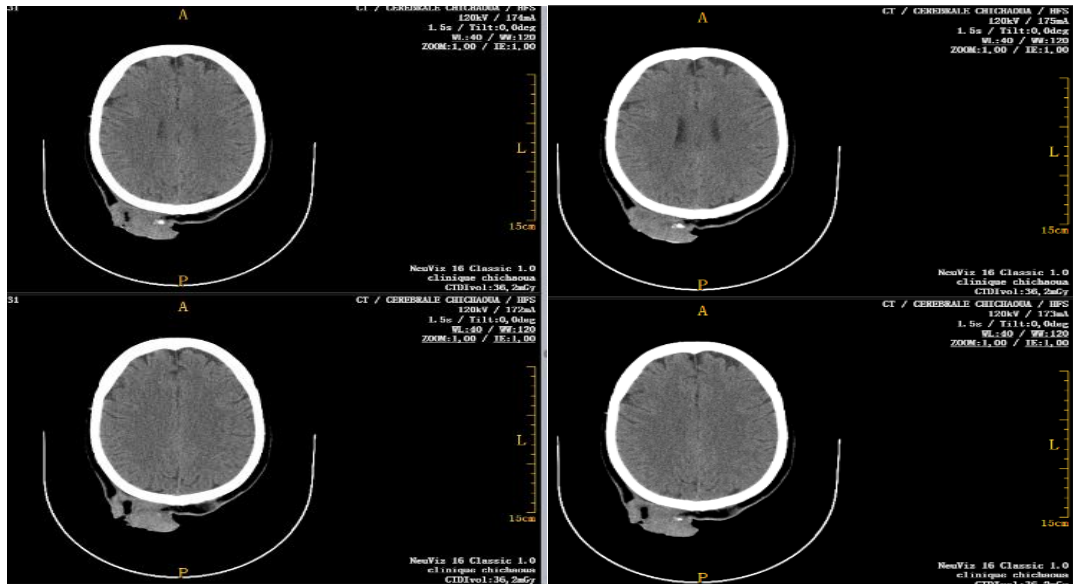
cerebral CT scan the patient was operated, the surgical procedure included tumorexcision with removing the periosteum and the external table of the bone for the biggest lesion and simple excision for the other cysts. (figure3).
